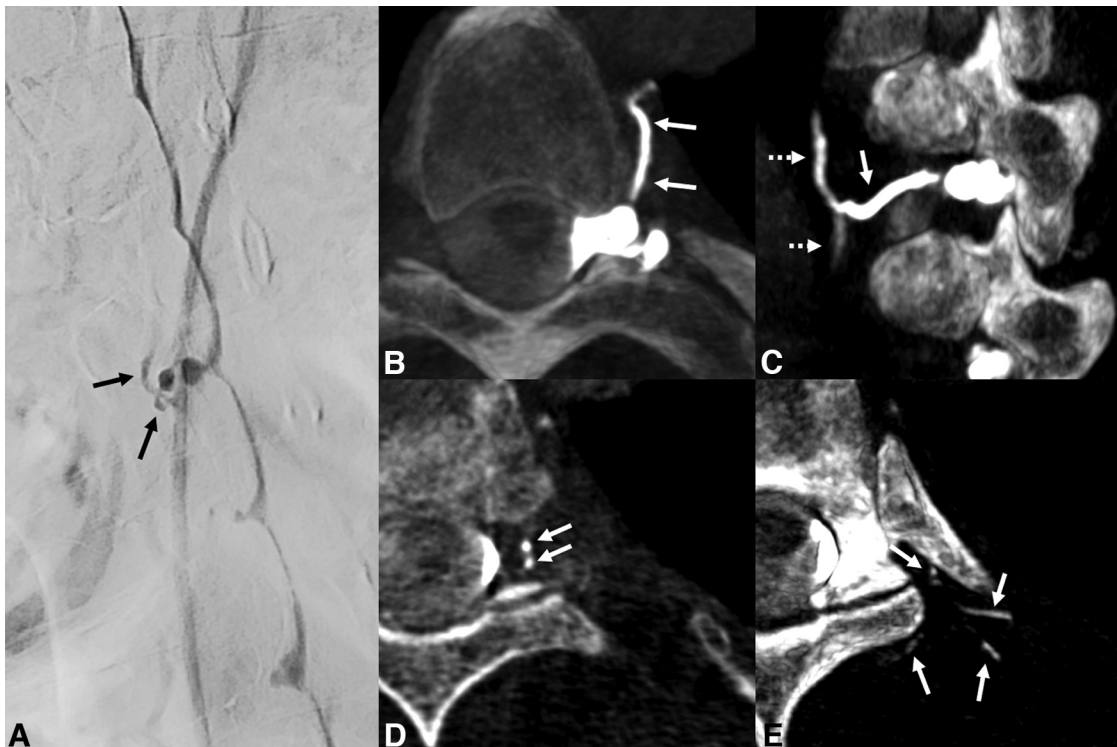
Left T4 CSF-venous fistula seen on digital subtraction myelography and CB-CTM. Left lateral decubitus digital subtraction myelogram (A) demonstrates curvilinear venous opacification adjacent to a left T4 diverticulum (A, arrows), compatible with a CVF. High-resolution CBCT was performed next after centering the flat panel detector over the level of T4, with imaging performed during active injection of 4 mL Omnipaque 300. Axial (B, D, and E) and sagittal (C) reformatted CBCT images demonstrate a definitive left T4 CVF involving the paraspinal segmental vein (B and C, arrows), the hemiazygos vein (C, dashed arrows), the internal epidural venous plexus (D, arrows), and small lateral and paraspinal muscular venous branches (E, arrows).
